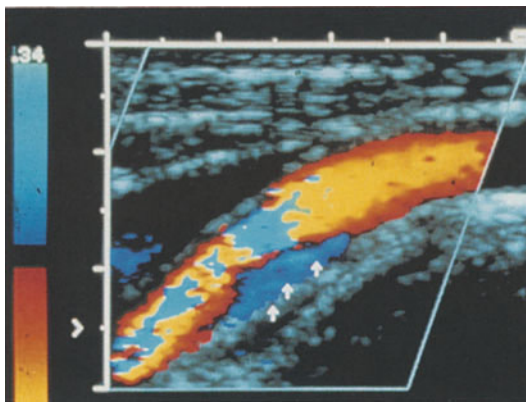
Both flow separation (white arrows) and aliasing are shown in this single image of a normal carotid bulb; the aliasing is due to low Doppler angle values along the more distal portions of the vessel as it curves into the path of the beam
